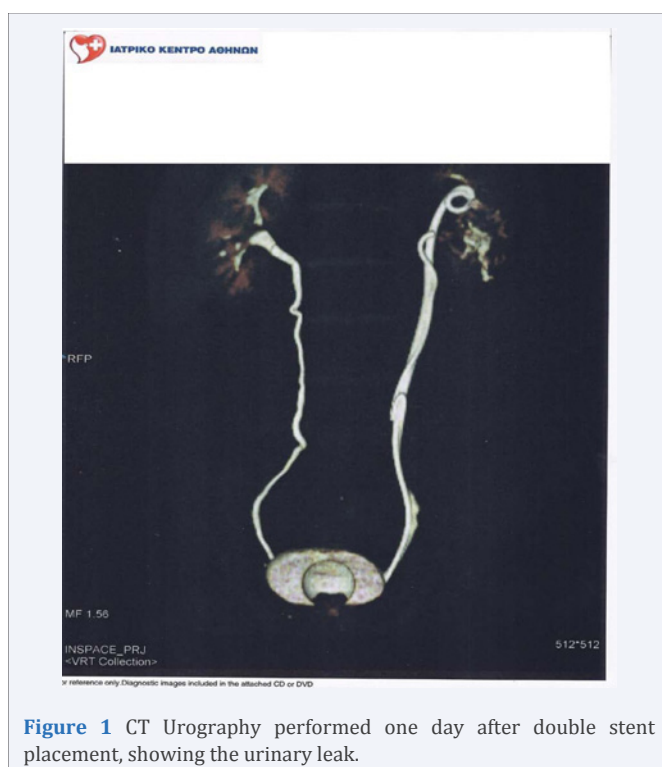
CT Urography performed one day after double stent placement, showing the urinary leak.
